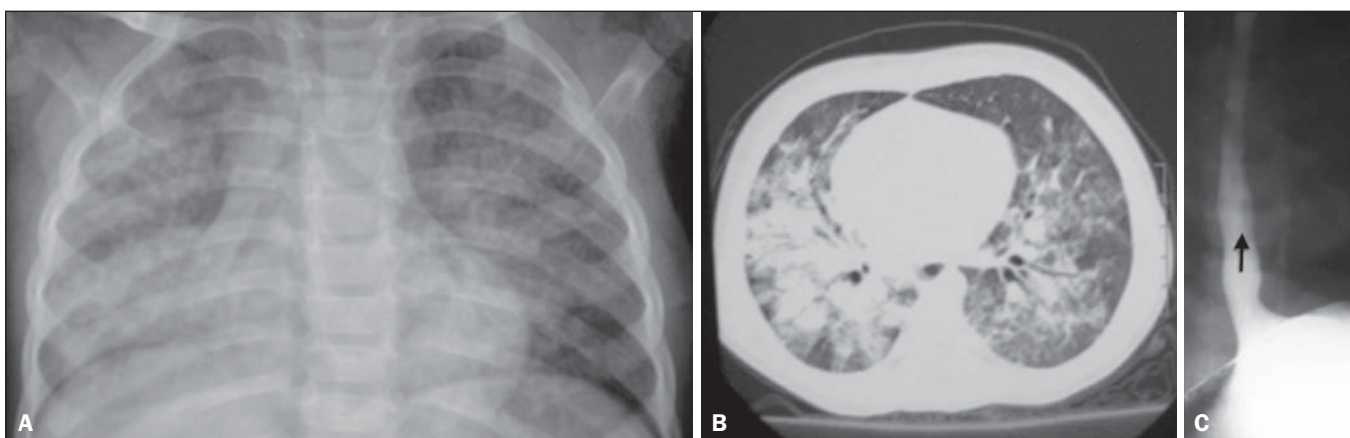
A twenty-month-old female child presenting with fever and cough. A: Anteroposterior chest radiography revealing the presence of bilateral, diffuse, ill defined, coalescent opacities in the middle lobe, conditioning the partial fading of the cardiac silhouette. B: Computed tomography, axial section identifying bilateral, predominantly central consolidations with air bronchograms. C: EGDS demonstrating reflux. As no clinical and radiological improvement was observed after antibiotic therapy, lung biopsy was indicated and showed foreign body granulomas and vegetal fibers presumably coming from gastroesophageal reflux. After appropriate treatment, clinical and radiological healing was observed.
